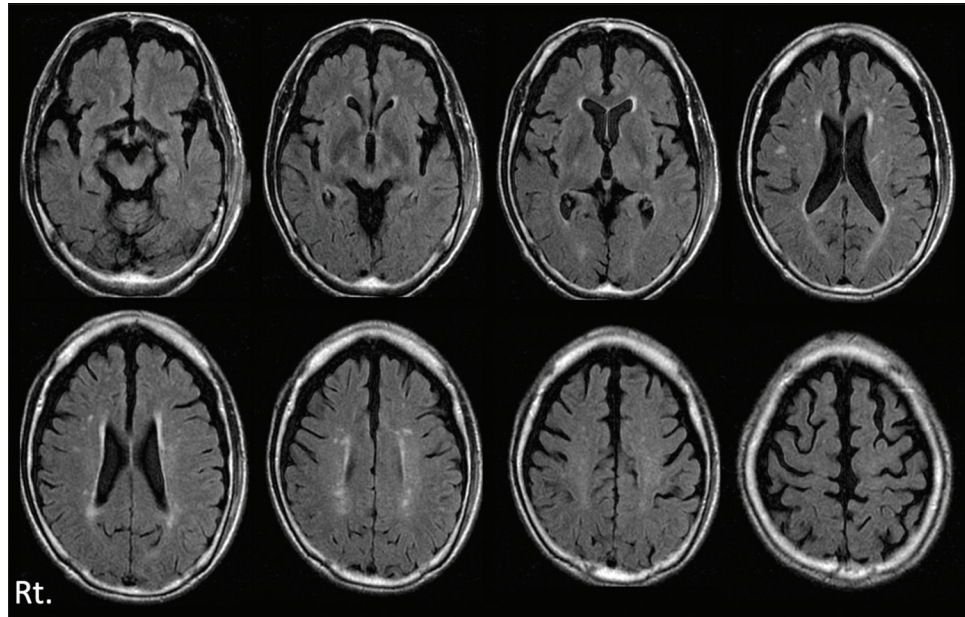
Brain magnetic resonance imaging (FLAIR) on day 2 after head injury, it revealed no hemorrhagic lesions including contusion.
